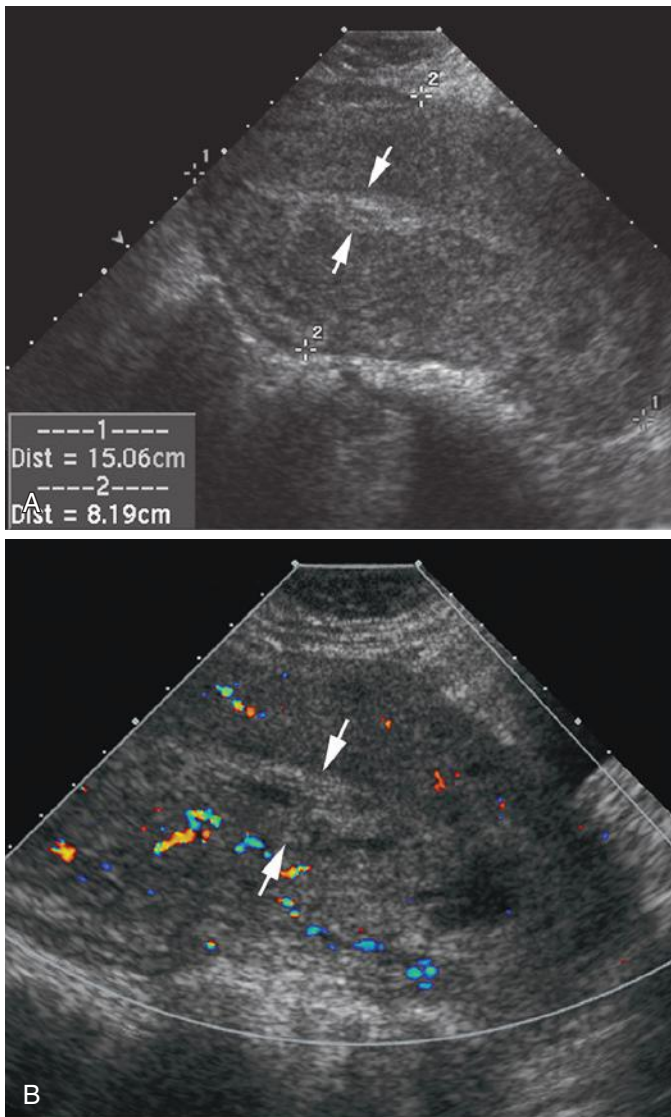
A, Sagittal sonogram from a patient presenting with bleeding 1 week postpartum. Tissue (*arrows*) was seen within the endometrial cavity, which is distended, measuring 15 mm. B, Corresponding color Doppler imaging demonstrated no evidence of blood flow within the tissue (*arrows*). This represented blood clots without retained products of conception.
